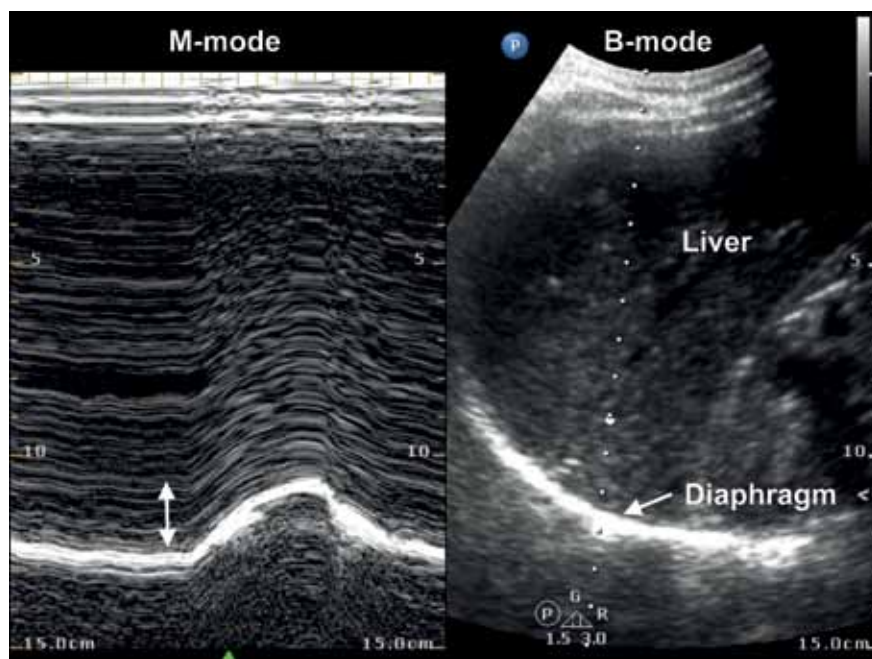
B-mode (right) and M-mode (left) ultrasound images of the diaphragm. The M-mode image shows downward diaphragm excursion during inspiration, i.e. towards the ultrasound probe positioned subcostally.
